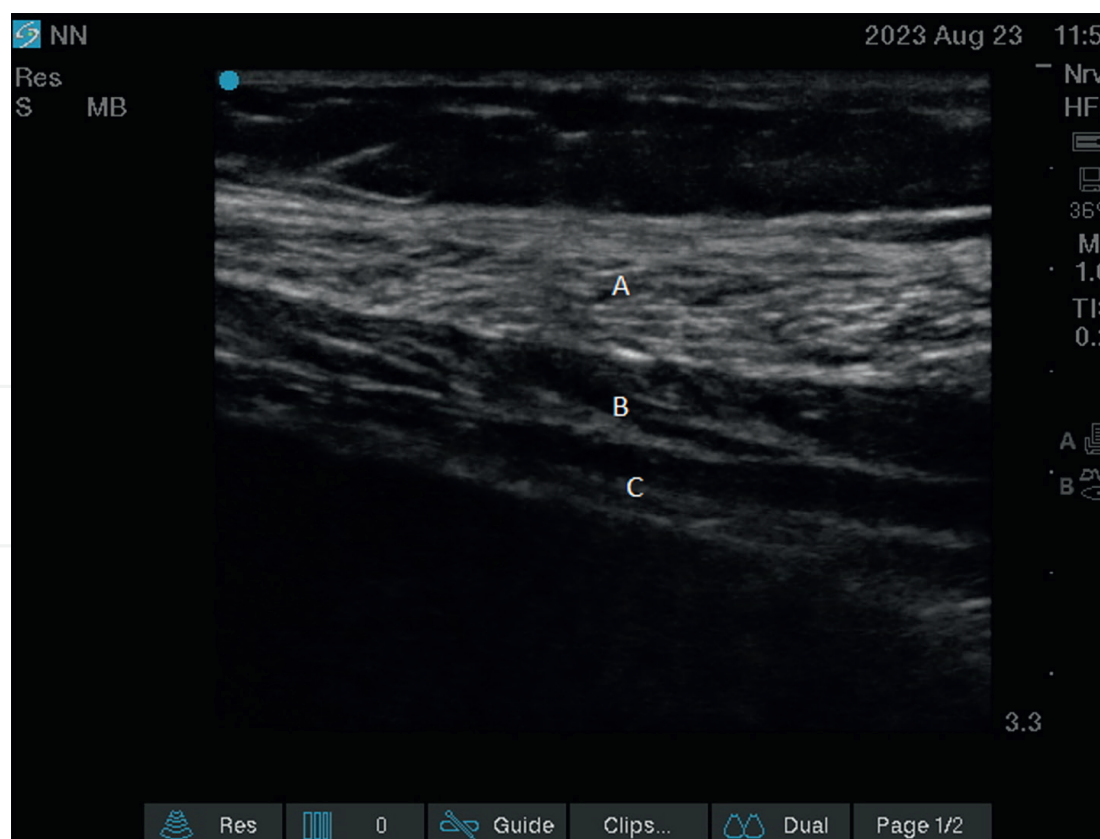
Ultrasound image (linear ultrasound probe) visualised all three muscles of the abdominal wall: external oblique (A), internal oblique (B), and transversus abdominis muscle (C). The space between the internal oblique and transversus abdominis muscles (transversus abdominis plane) is a target area for applying a local anaesthetic. (Author's archive).
